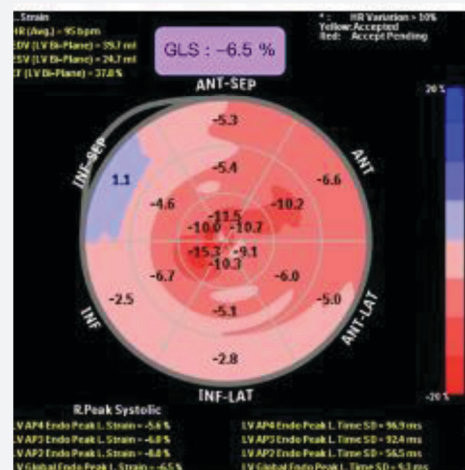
Speckle-tracking echocardiography shows markedly reduced global longitudinal strain (GLS) of -6.5%, indicating subclinical LV systolic dysfunction. The polar strain map demonstrates apical sparing with a characteristic "cherry-on-top" pattern.
